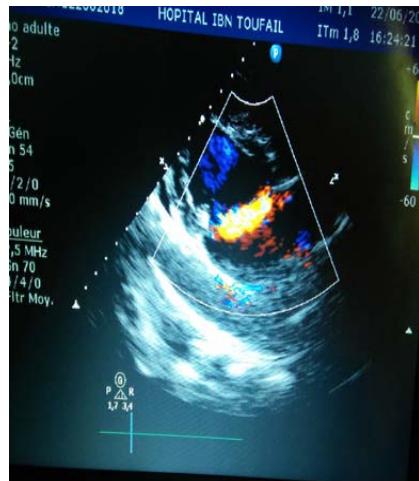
Parasternal long axis view showing P2 prolapse of mitral valve P2.
